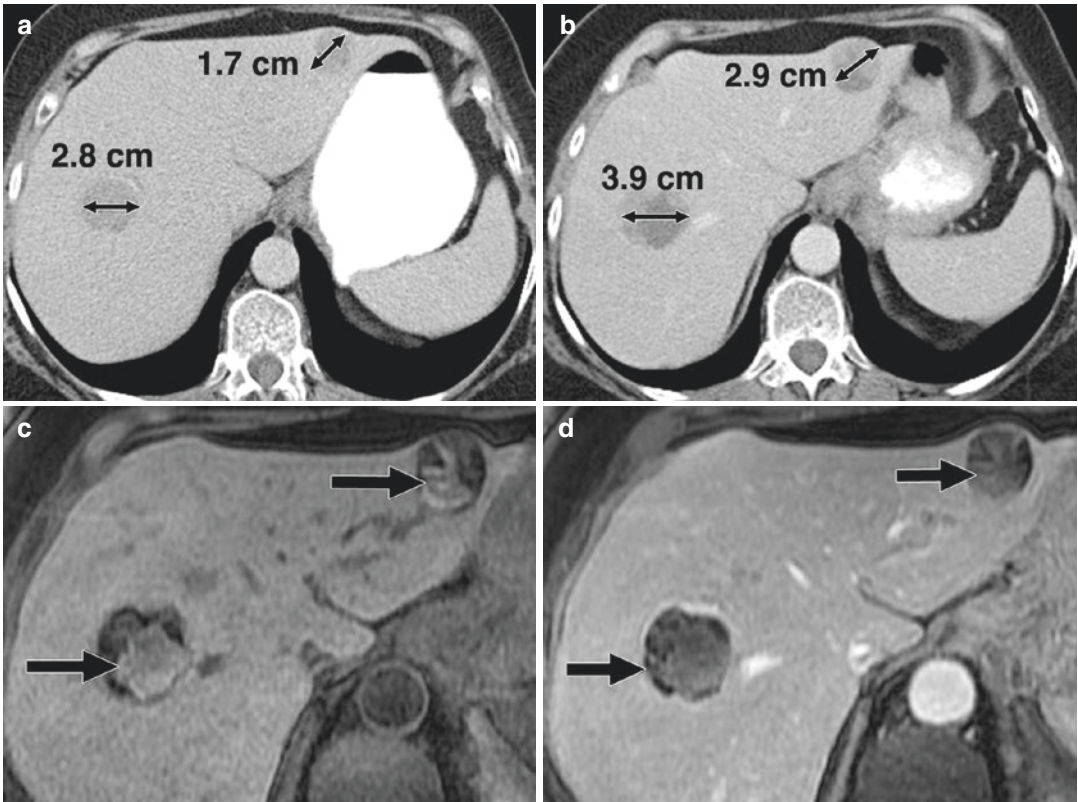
Paradoxical increase in size of target lesions after targeted therapy in a 69-year-old woman with melanoma. (a) Baseline CT scan of abdomen shows two metastatic lesions in liver. (b) Follow-up CT scan obtained after treatment with tyrosine kinase inhibitor, sorafenib, shows increase in size of metastatic liver lesions, measuring 3.9 cm at follow-up compared with 2.8 cm at baseline and 2.9 cm compared with 1.7 cm at baseline. Note
